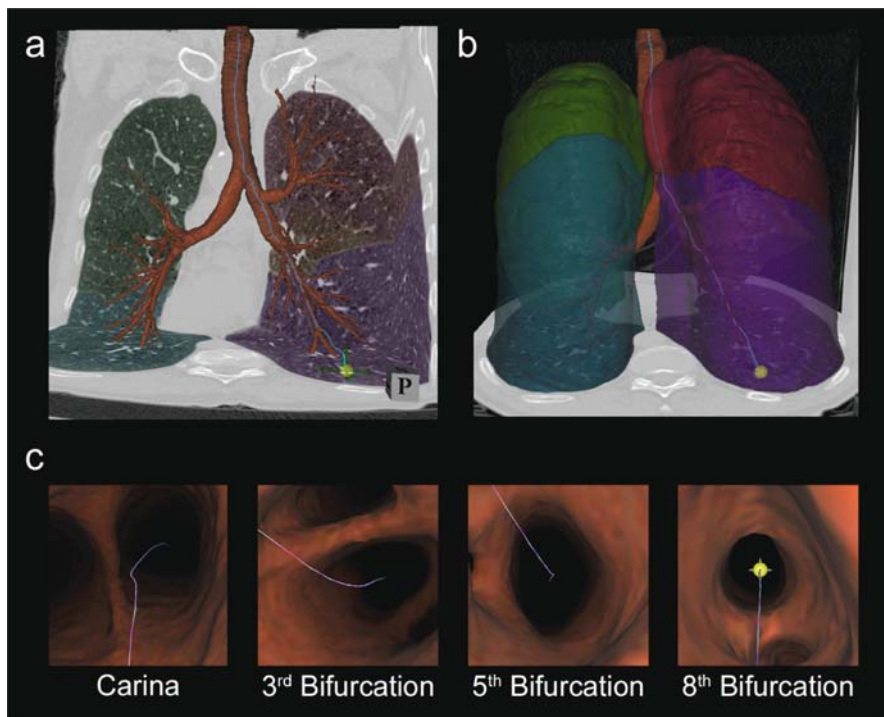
(a–c) Automated virtual path finding to a nodule of interest. The path is indicated in *blue* and the nodule is indicated by the *yellow sphere*. (a) Represents the automated segmented airways and direction path (*blue*), with the original CT data color coded for individual lobes. (b) Represents a volume reconstruction of the airways and the lung into its individual lobes. (c) Represents the Carina, 3rd, 5th, and 8th bifurcation leading toward the nodule indicated by the *yellow sphere*. Images courtesy of VIDA diagnostics
